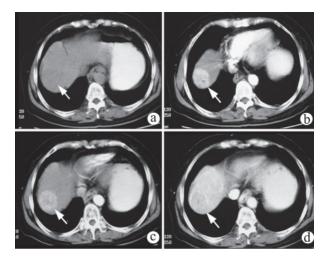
Capsule appearance of HCC (Arrow). (a) Precontrast CT showed an equivocal hypoattenuation nodule. (b) In early arterial phase, the nodule showed remarkable and heterogeneous hyperenhancement. (c) In late arterial phase, the nodule showed less enhancement but still higher than the background liver. (d) In portal venous phase, the nodule demonstrated unequivocal washout and a hyperattenuation ring was seen along margin of HCC namely capsule appearance.
